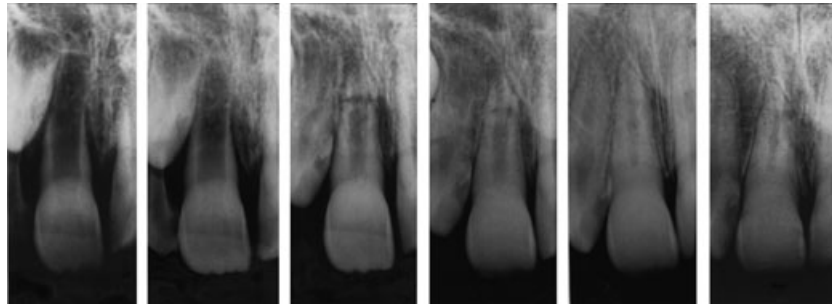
Standardized radiographic taking and resizing of radiographs adds to the consecutive overview of post-trauma healing events. Postoperative healing events are shown for a replanted central incisor over a long period of time.
